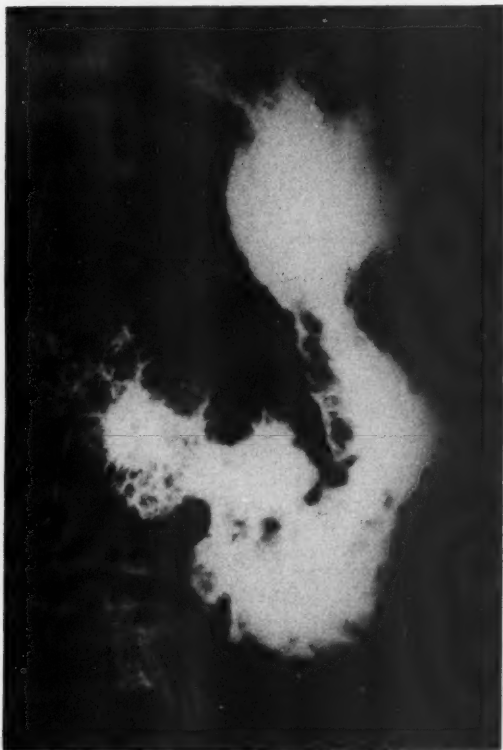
Roentgenologic examination of the stomach reveals the typical appearance of giant rugae.
